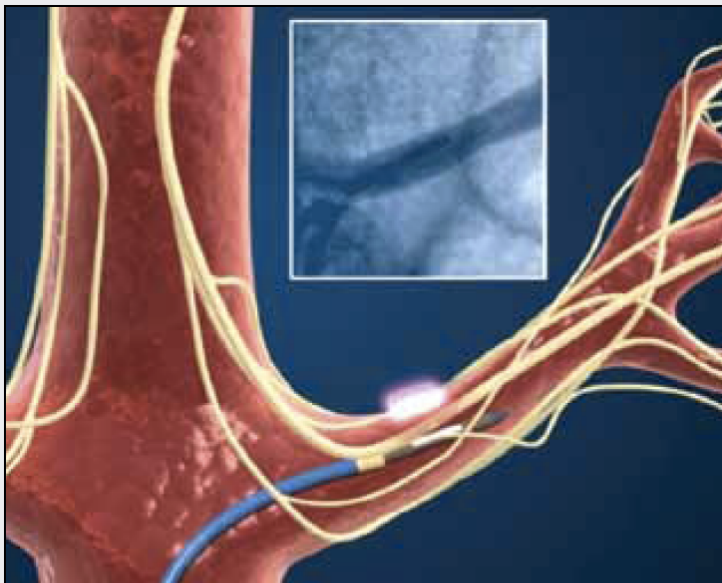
The 0.014-inch guidewire-based TIVUS catheter positioned within the renal artery lumen through a 6-F flexible sheath. Note that the ultrasound-emitting element (positioned superiorly) does not make direct contact with the vessel wall (inset).
